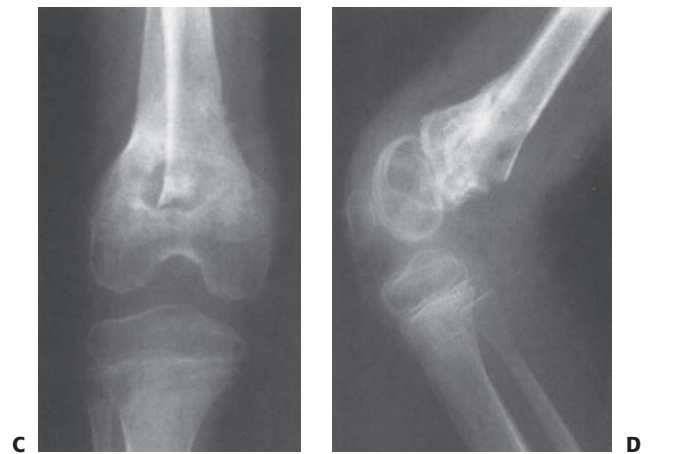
A: Completely displaced Salter–Harris type II fracture of the distal femur in a 6-year-old girl whose foot was on the back of the driver’s headrest when the automobile in which she was riding was involved in an accident. B: Ecchymosis in the popliteal fossa and anterior displacement of the distal femur are evident. Clinical examination revealed absence of peroneal nerve function and a cold, pulseless foot. The fracture was irreducible by closed methods and required open reduction, internal fixation, and repair of a popliteal artery laceration. C, D: Follow-up x-rays show excellent healing after pin removal. The reduction had been incomplete with 25 degrees of posterior angulation remaining. E, F: Four years later, remodeling has occurred and no growth disturbance is noted. Results such as this cannot be relied upon, and early anatomic reduction is recommended.
